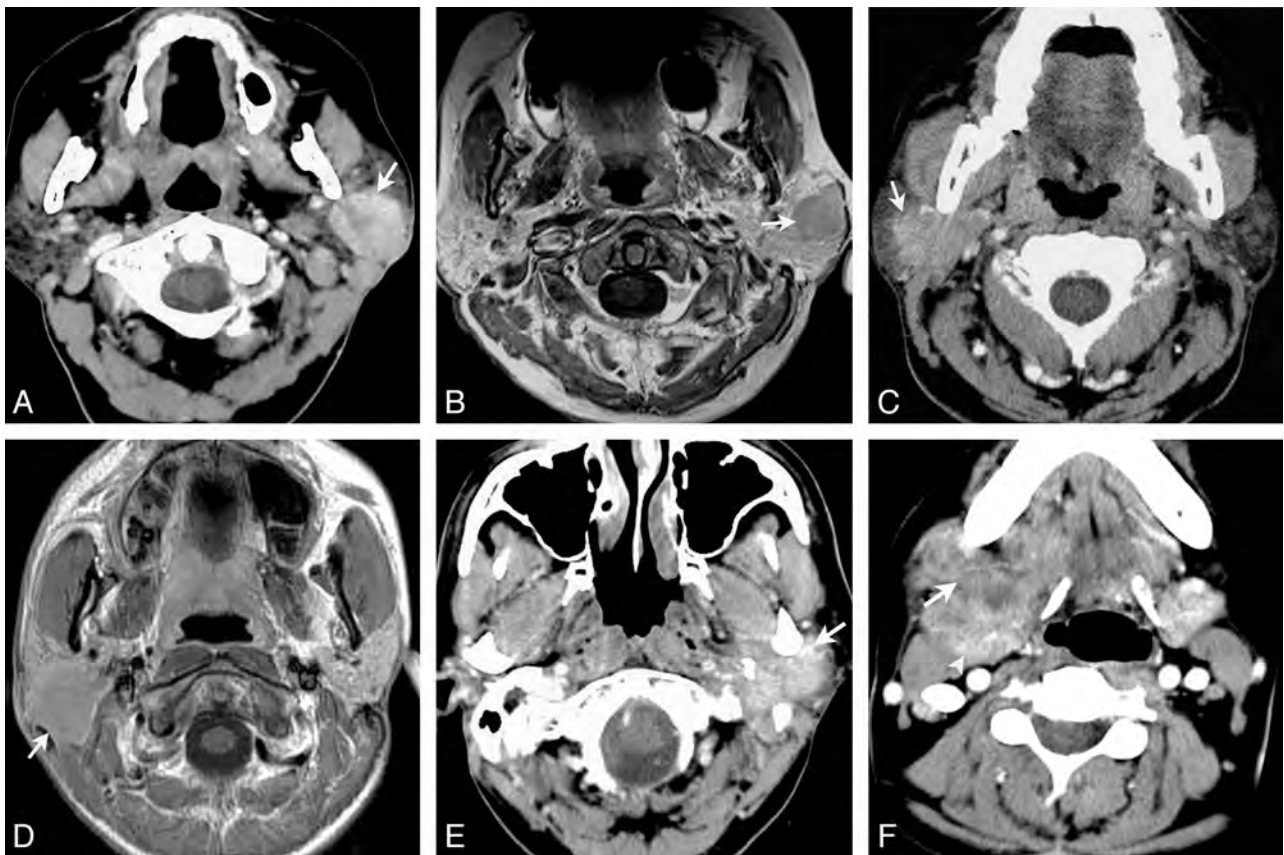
Morphologic patterns of salivary gland LECs. Type 1: Axial contrast-enhanced CT (A) and axial gadolinium-enhanced T1-weighted imaging (B) show round masses with well-defined margins located in the left parotid glands (arrows). Type 2: Axial contrast-enhanced CT (C) and axial gadolinium-enhanced T1-weighted imaging (D) show masses with plaque-like (C) and lobulated (D) shapes and partially defined margins located in the right parotid glands (arrows). Type 3: Axial contrast-enhanced CT shows masses with irregular shapes, ill-defined margins, and diffuse invasive growth (arrow) located in the left parotid (E) and right submandibular (F) glands, respectively. Normal submandibular gland tissue is displaced posteriorly and medially (arrowhead).
